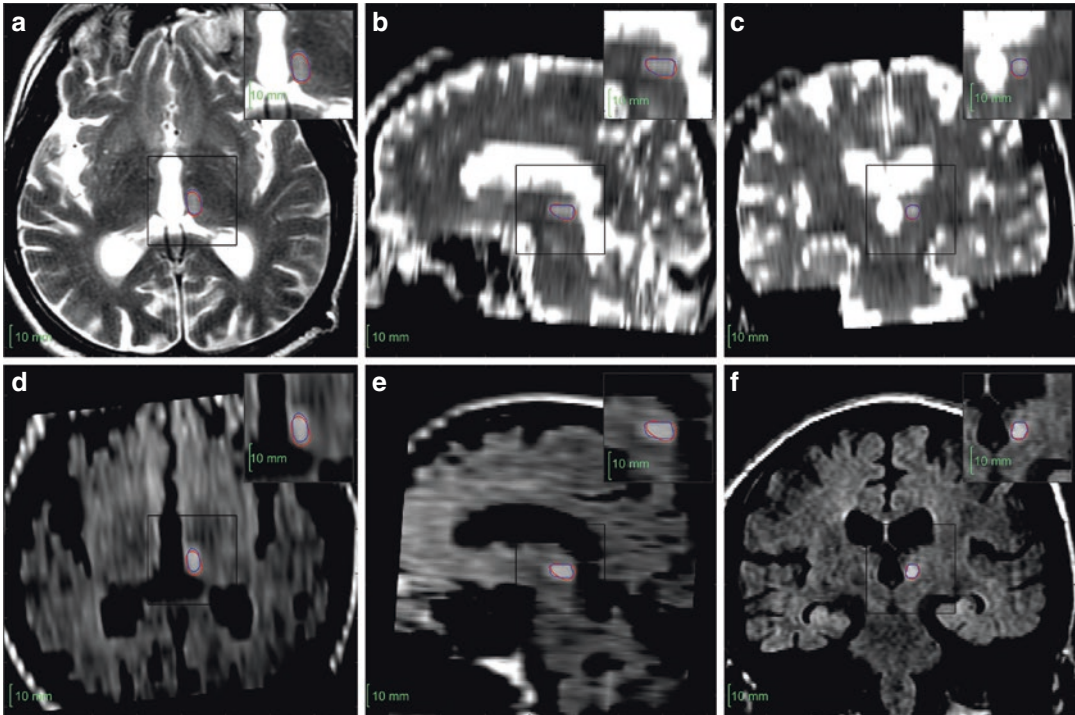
Axial, sagittal and coronal T2 (top) and FLAIR (bottom) MR images of a patient treated for neuropathic pain, acquired 6 months post-treatment. The prescription dose is depicted with red line and the delineated target
